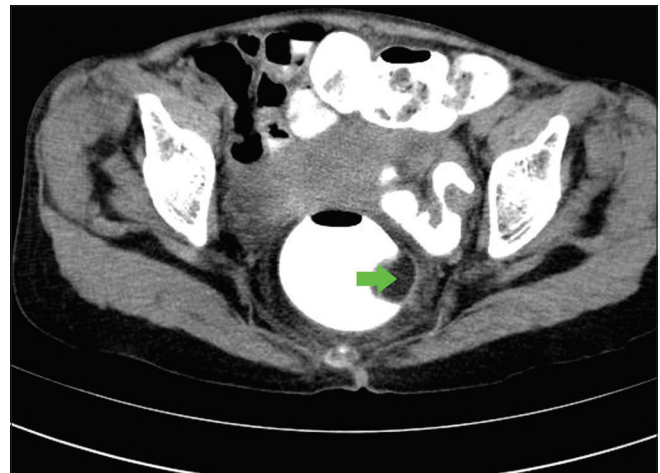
Contrast CT of abdomen showing a sub-mucosal rectal mass (green arrow)
